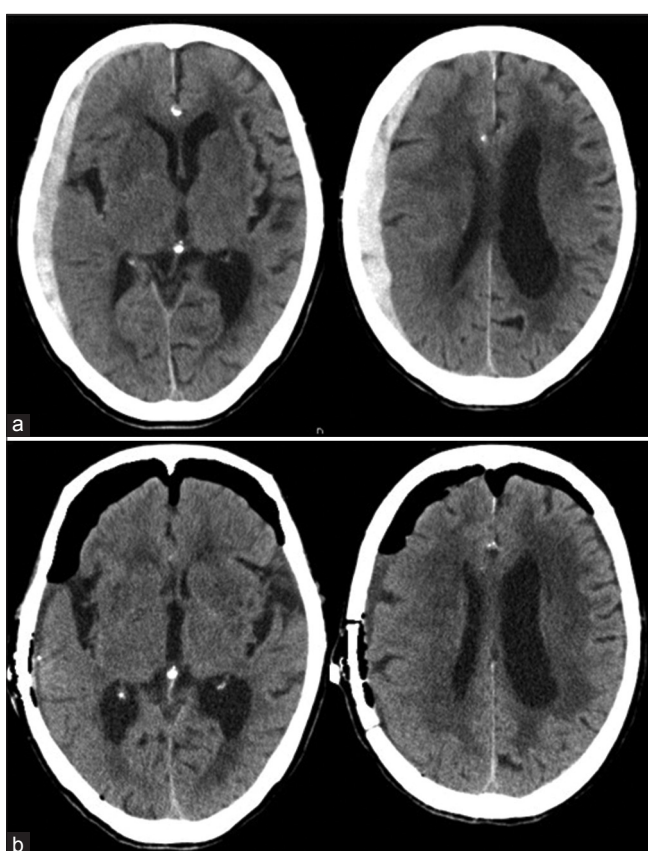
(a) Head computed tomography (CT) showing a thick acute subdural hematoma and mild midline shift at the time of admission in case 5. (b) Follow-up head CT showed sufficient hematoma removal and improved midline shift after the procedure.
